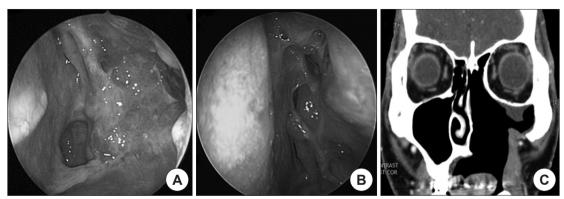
Post operation 9 month findings. A: Follow up endoscopic findings of left maxillary sinus. B: Follow up endoscopic findings of left ethmoidal sinus & frontal recess. C: Follow up PNS CT enhanced coronal imagina.
